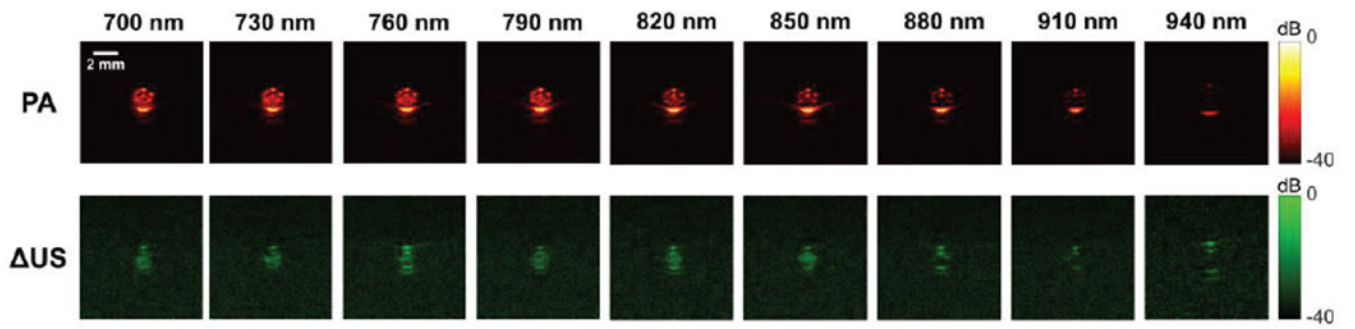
Photoacoustic and differential US (Δ US) images of a capillary tube containing PFHnDs. The images were obtained at different optical wavelengths ranging from 700 nm to 940 nm. Each US image was generated by taking a difference between first two post-laser ultrasound frames.
